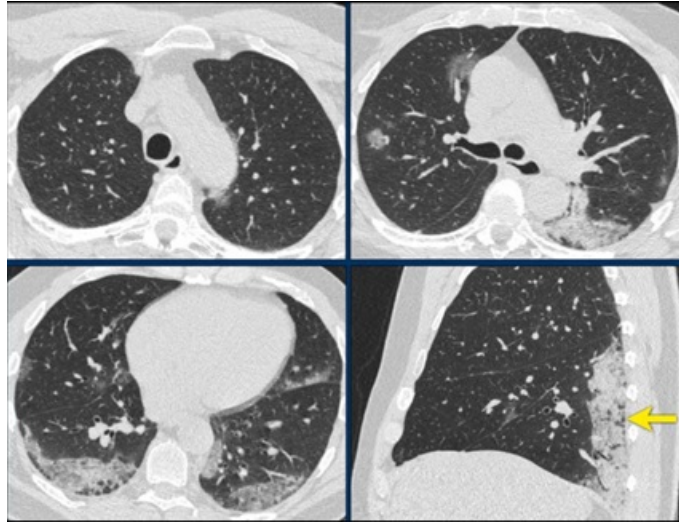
A 59-year-old male patient presented with fever and non-productive cough lasting for 1 week. PCR test was negative. In thorax CT taken due to clinical suspicion; GGO and consolidation were noted in the posterior segments of the lower lobe. RT-PCR turned out to be positive 2 days later.
